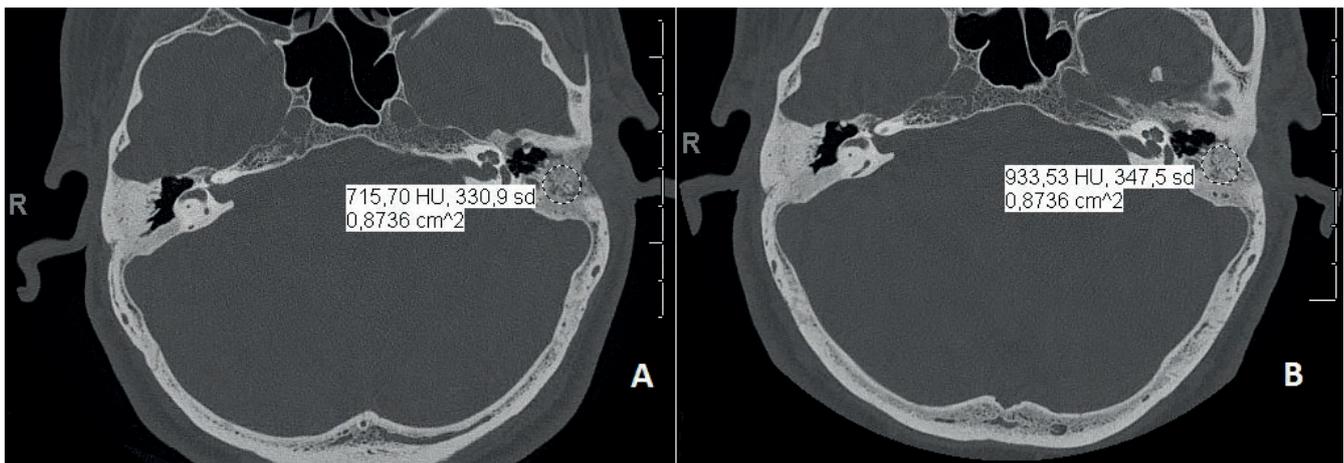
Computed tomographic images at six (A) and 31 (B) months after obliteration surgery, showing an increase in bone graft density.
